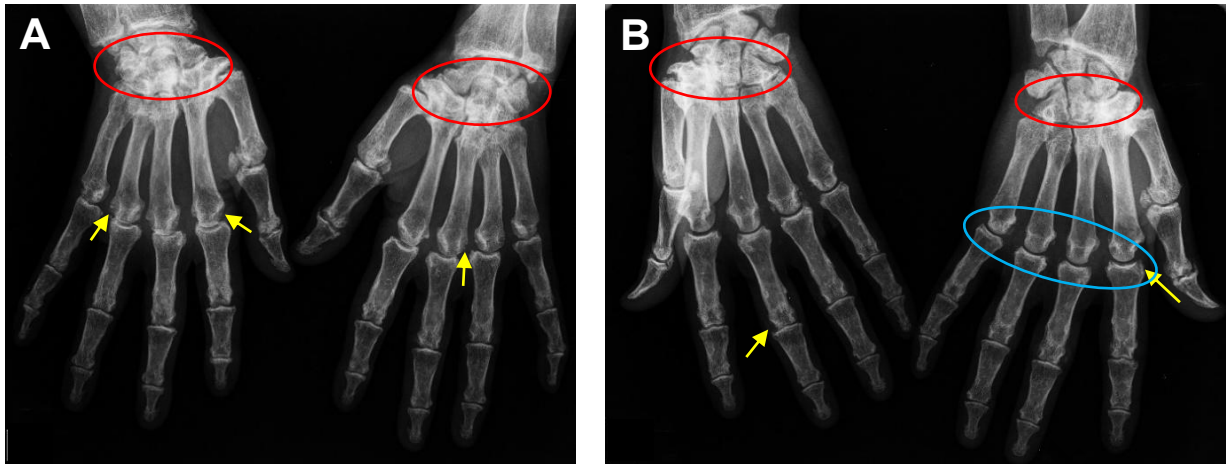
Hand radiographs consistent with seronegative rheumatoid arthritis.
